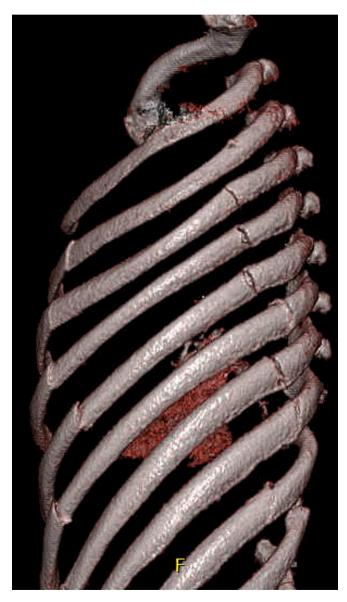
Preoperative 3D reconstruction of CT of chest wall demonstrating left-sided segmental fractures to ribs 4 through 7.
